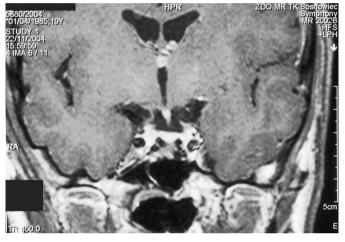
Frontal T₁-weighted MRI scan of the empty sella after operation (case 3).
